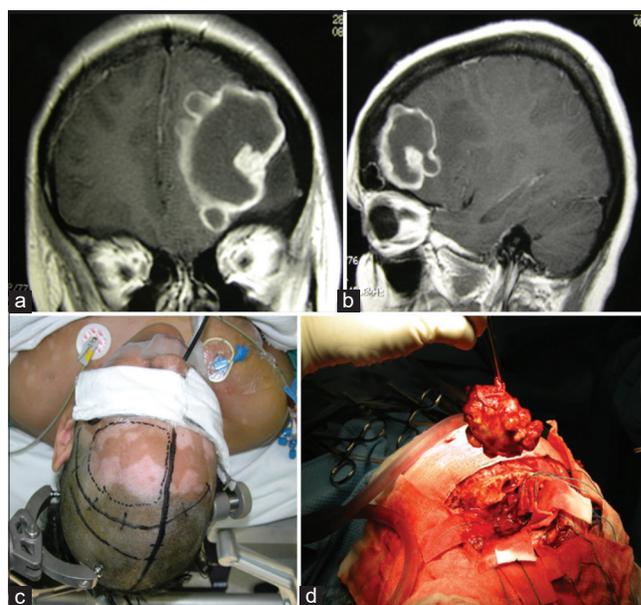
Case 4: (a) Magnetic resonance imaging (MRI) brain with gadolinium, coronal view showing large dural based cystic lesion in the left frontal area suggestive of cystic meningioma Type 1 Nauta classification, (b) MRI brain with gadolinium, Sagittal view showed large left dural based frontal cystic lesion suggestive of cystic meningioma, (c) left frontal craniotomy under general anesthesia, (d) gross total excision of the lesion
